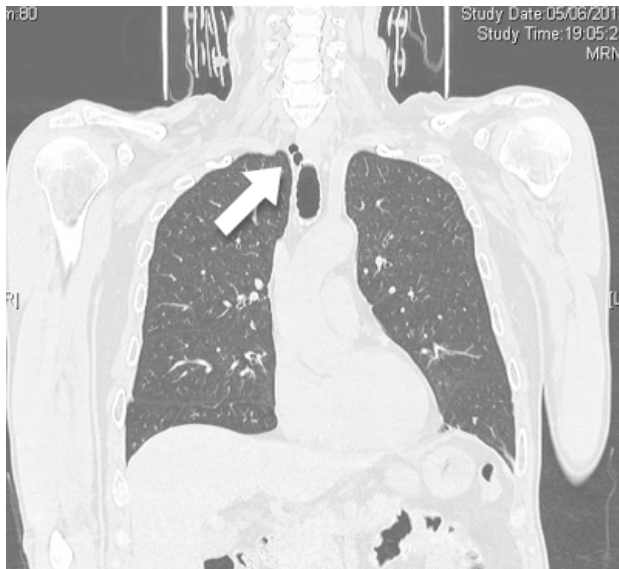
Tracheal diverticulum: CT frontal scan showing a right paratracheal air collection (arrow).
